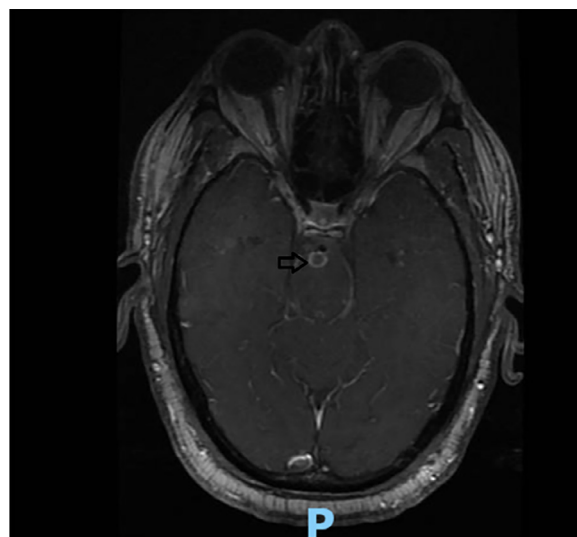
MRI of the brain with and without contrast transverse section showing 9-millimeter ring enhancing lesion in the pons along with right pontine infarct (highlighted by black arrows).
